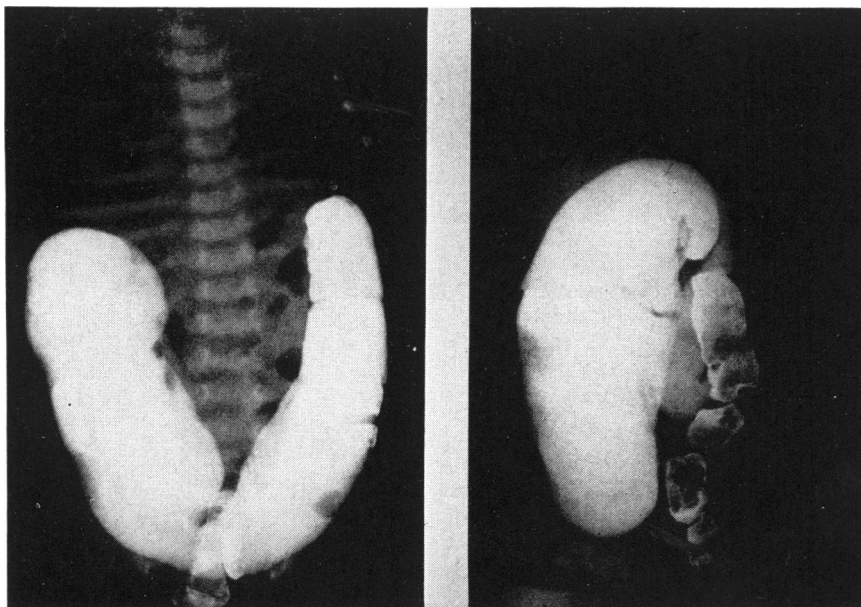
Roentgenograms of a 4 weeks old boy who was admitted following the administration of a barium enema at another hospital. In the lateral projection the megacolon can be seen to start in the upper descending colon.
